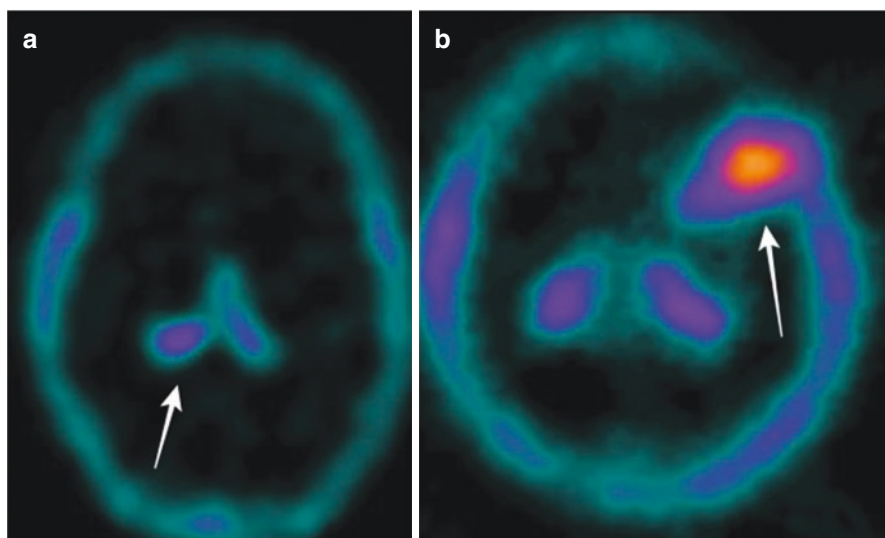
(a) Normal distribution of a technetium-labeled compound ($^{99\text{m}}\text{Tc}$ -Tetrafosmin) for brain SPECT imaging. There is uptake in structures lacking blood brain barrier such as the choroid plexus (arrow). In normal brain there is no tracer uptake, thus a neoplastic lesion can be readily identified. (b) A case of a recurrent glioblastoma exhibiting avid tracer uptake (arrow)
